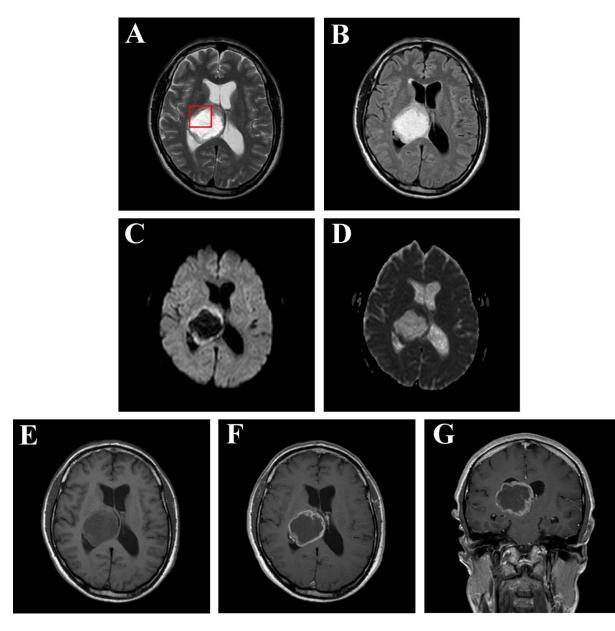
MRI of the brain demonstrating the irregularly-enhanced right thalamic mass, using the following sequences: (A) axial T2 image, (B) axial FLAIR image, (C) axial DWI image, (D) correlated ADC map, (E) axial T1 image, (F) post-contrast axial T1 image, and (G) post-contrast coronal T1 image.
